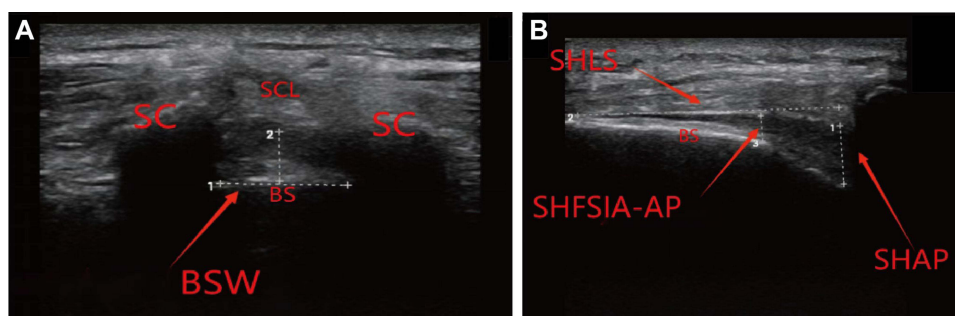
Representative images of ultrasound measurements of the anatomical dimensions of the sacral canal. (A) Ultrasound image of the sacral hiatus in the transverse plane. (B) Ultrasound image of the sacral hiatus in the longitudinal plane.
